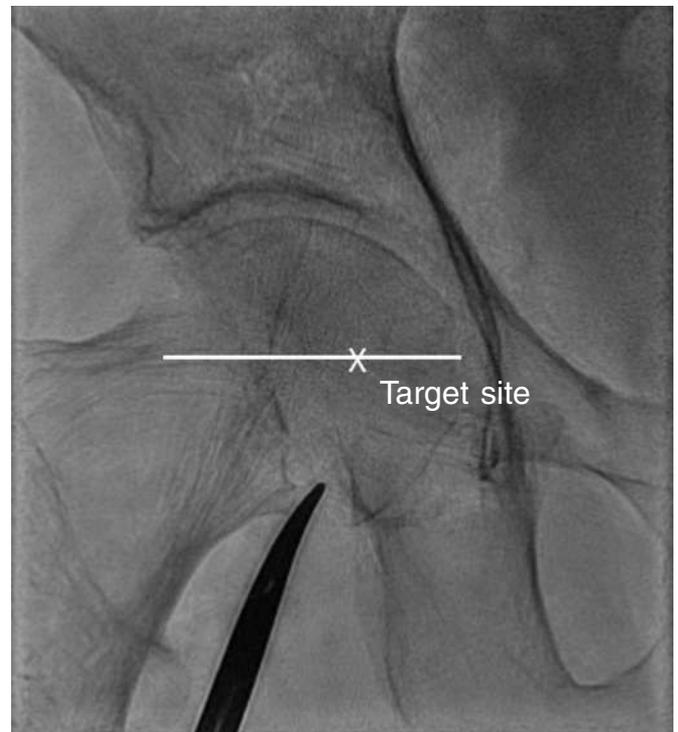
Radiographic references of punctures on the femoral artery.
